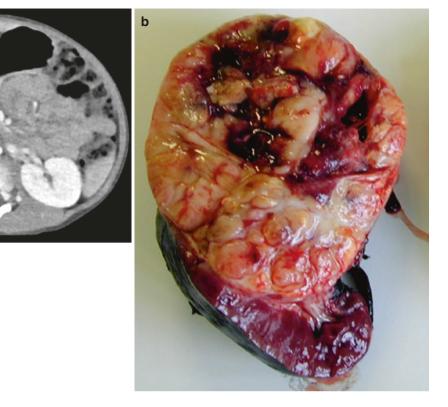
Radiological and gross findings in Wilms' tumour. (a) MRI of the abdomen showing a large renal mass arising from the upper pole of the kidney. (b) Macroscopic appearance of Wilms' tumour arising from the upper pole of the kidney
